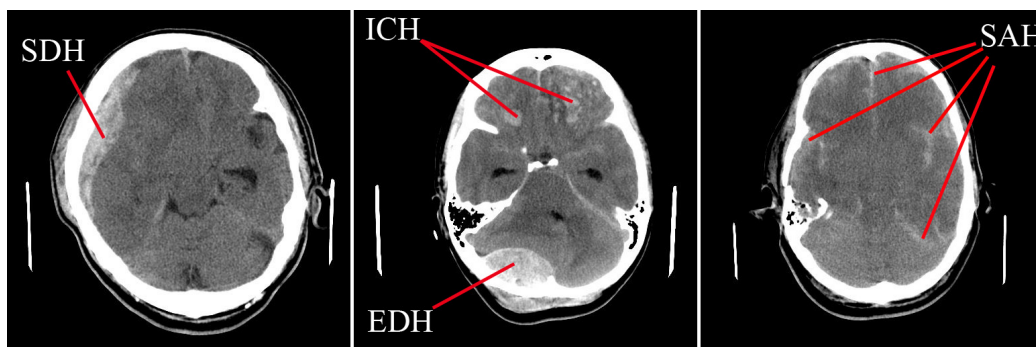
Annotation results of some brain CT images
